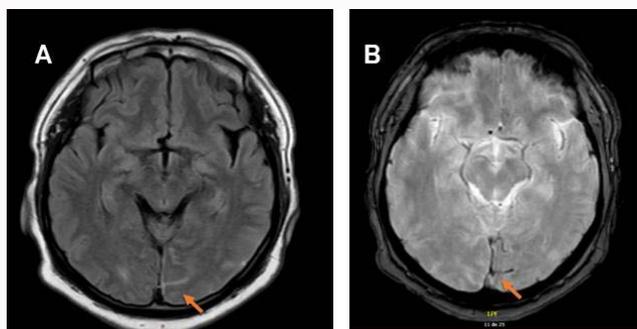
Simple brain MRI. A: MRI FLAIR sequence showing a left occipital sulcal linear hyperintensity (Red arrow). B: MRI GRE sequence showing a left occipital linear hypointensity (Red arrow).
